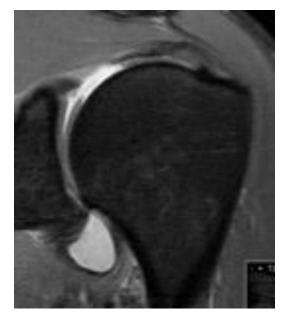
MRI with intra-articular gadolinium application for better visualization of a chondral lesion at the humerus (ICRS type 4)
